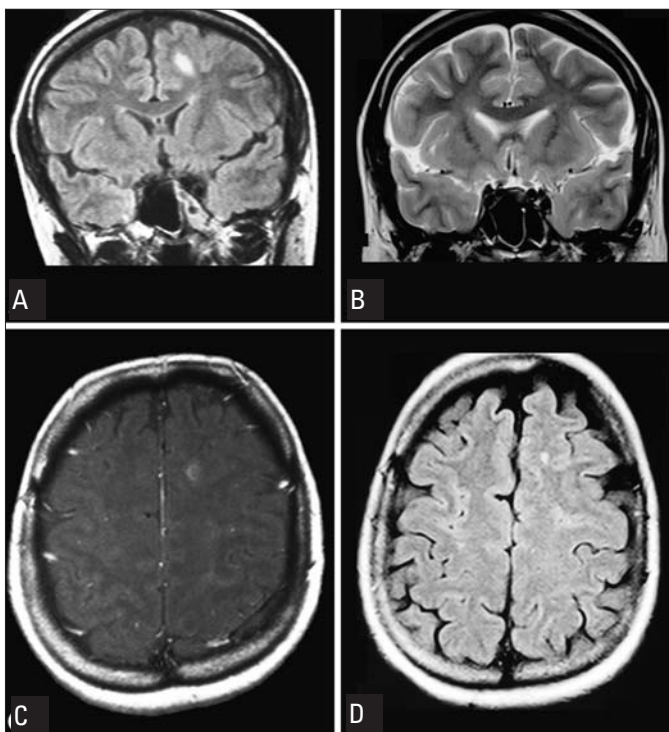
In June 2006, cranial MRI showed left frontal hyperintensity in coronal FLAIR images (A) and open ring contrast enhancing lesion in left frontal subcortical area in postcontrast T1-weighted images (C). In October 2007, the lesions in the previous MRI were regressed in the similar sections in coronal T2-weighted images (B) and in axial T2-weighted images (D)
